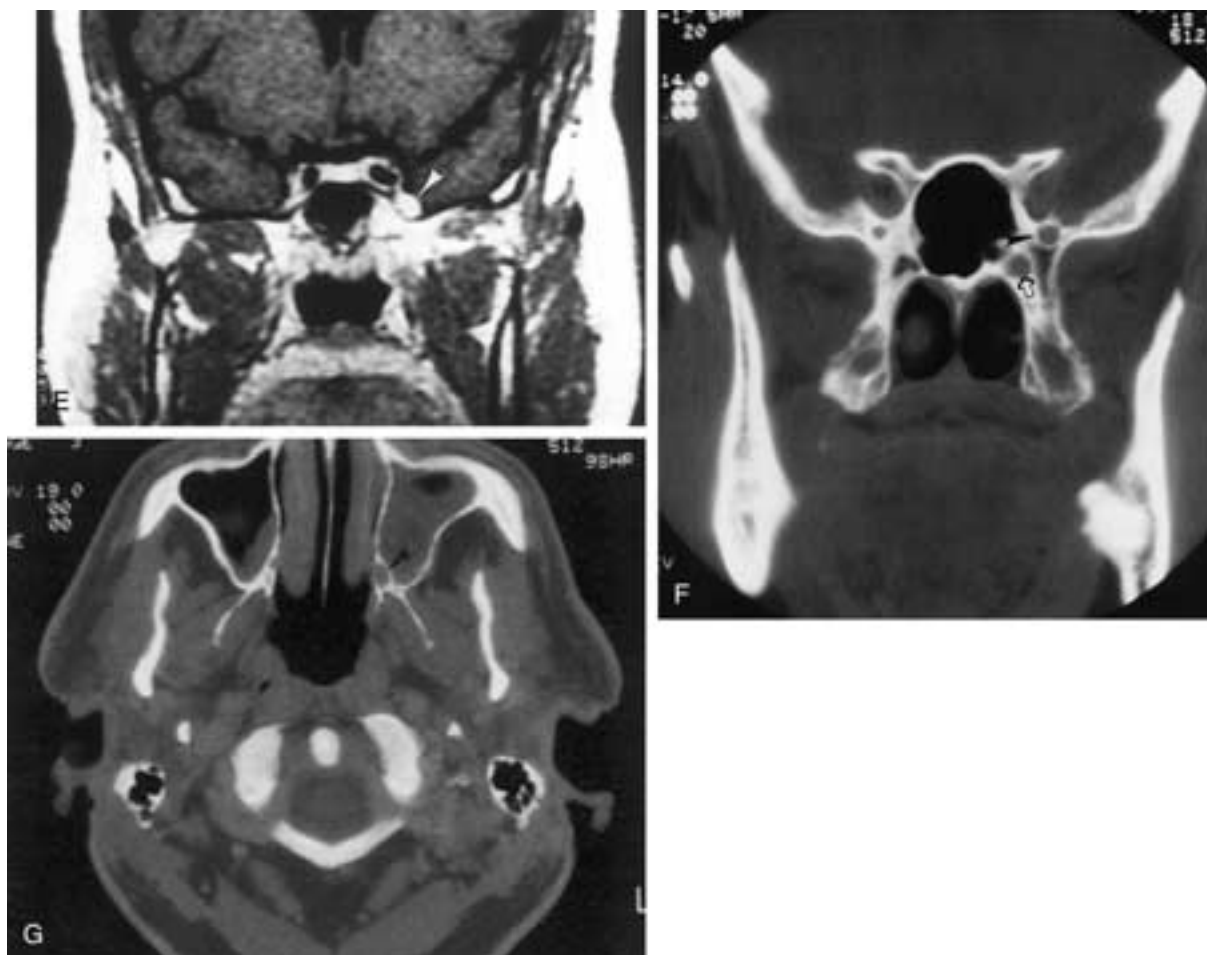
Continued.* E, Coronal MR T1-weighted postgadolinium image shows the enlargement of the second division of the trigeminal nerve just posterior (*white arrowhead*) to the foramen rotundum. The nerve is enlarged and enhances, indicating tumor involvement. F, Coronal bone algorithm shows enlargement of the foramen rotundum (*black arrowhead*) and the Vidian canal (*open black arrow*). This indicates tumor extension along both nerves. G, Enlargement of the lower pterygopalatine canal (*black arrowhead*), which connects the pterygopalatine fossa with the hard palate.
